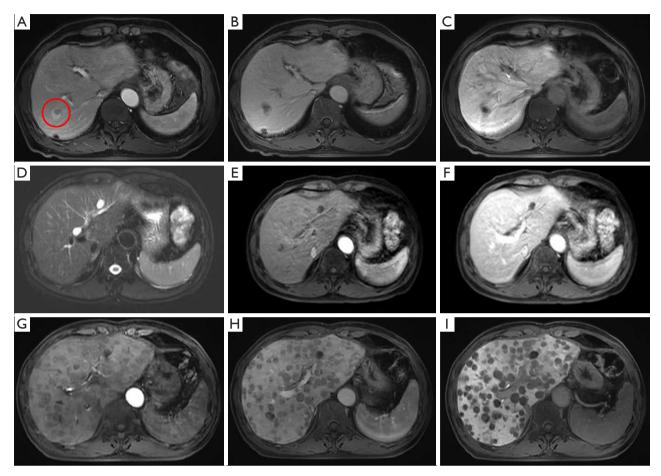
Migration of the Gd-EOB-DTPA-enhanced MRI before and after LT, and the recurrence in 2022. (A) MR enhanced scan arterial phase: there was early enhancement along the edges in S7 segment. The red circle highlights the lesion. (B) portal venous phase: early washout of the lesion. (C) MR enhanced scan of hepatobiliary specific phase: obvious low signal. (D-F) Routine review after LT in June 2022. (G-I) The liver showed diffuse lesions with partial internal bleeding, which were newly developed HCC compared to the previous examination, suggesting multiple intrahepatic metastases. Gd-EOB-DTPA, gadolinium-ethoxybenzyl diethylenetriamine pentaacetic acid; MRI, magnetic resonance imaging; LT, liver transplantation; MR, magnetic resonance; HCC, hepatocellular carcinoma.
